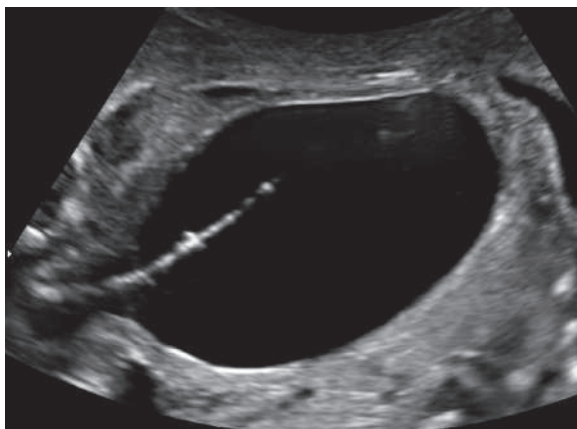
Ultrasound image showing fetoscopic placement of a transurethral vesicoamniotic shunt in a patient with posterior urethral valves. (Courtesy Dr. Foong Lim, Cincinnati Fetal Center at Cincinnati Children's Hospital Medical Center.)
